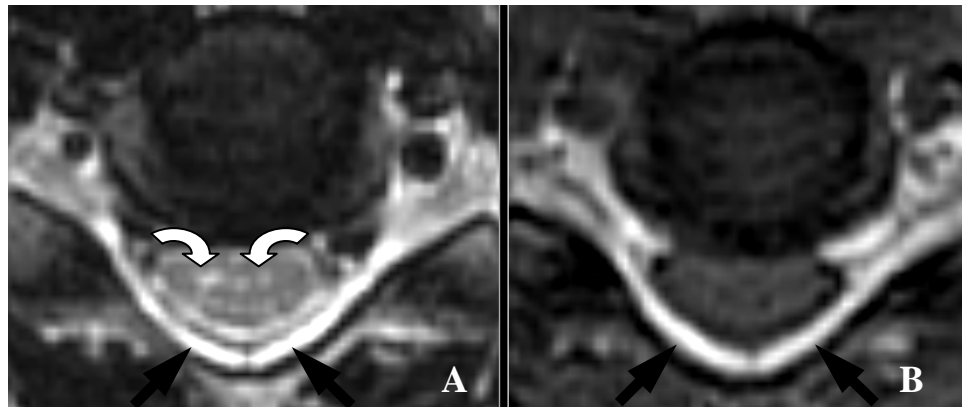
Flexion axial MR images at C4 to C5 disc level in a 21-year-old patient with progressive right-hand and forearm weakness and wasting for 3 years. A, T2-weighted (3300/114, repetition time/echo time) and B, contrast-enhanced (600/18) MR images show hyperintense signal near the bilateral of the side anterior horns (curved arrows in A) and enhancement of engorged posterior epidural space (arrows in A and B).
